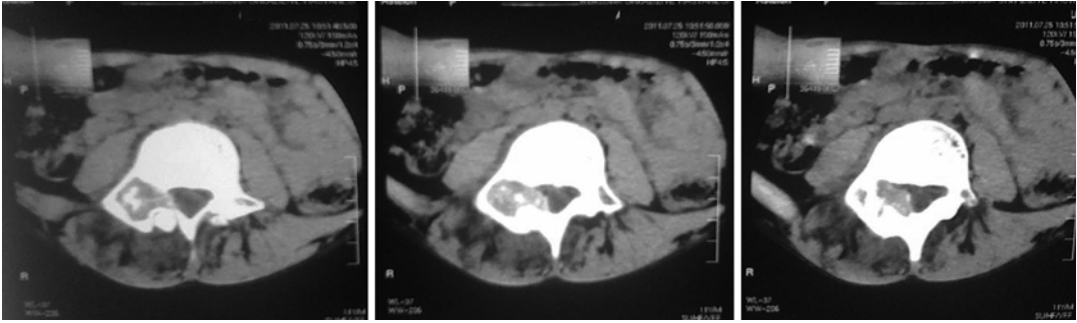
Osteoblastoma. CT scans show a lytic lesion localized in posterior vertebral column, with intralesional punctate calcifications
